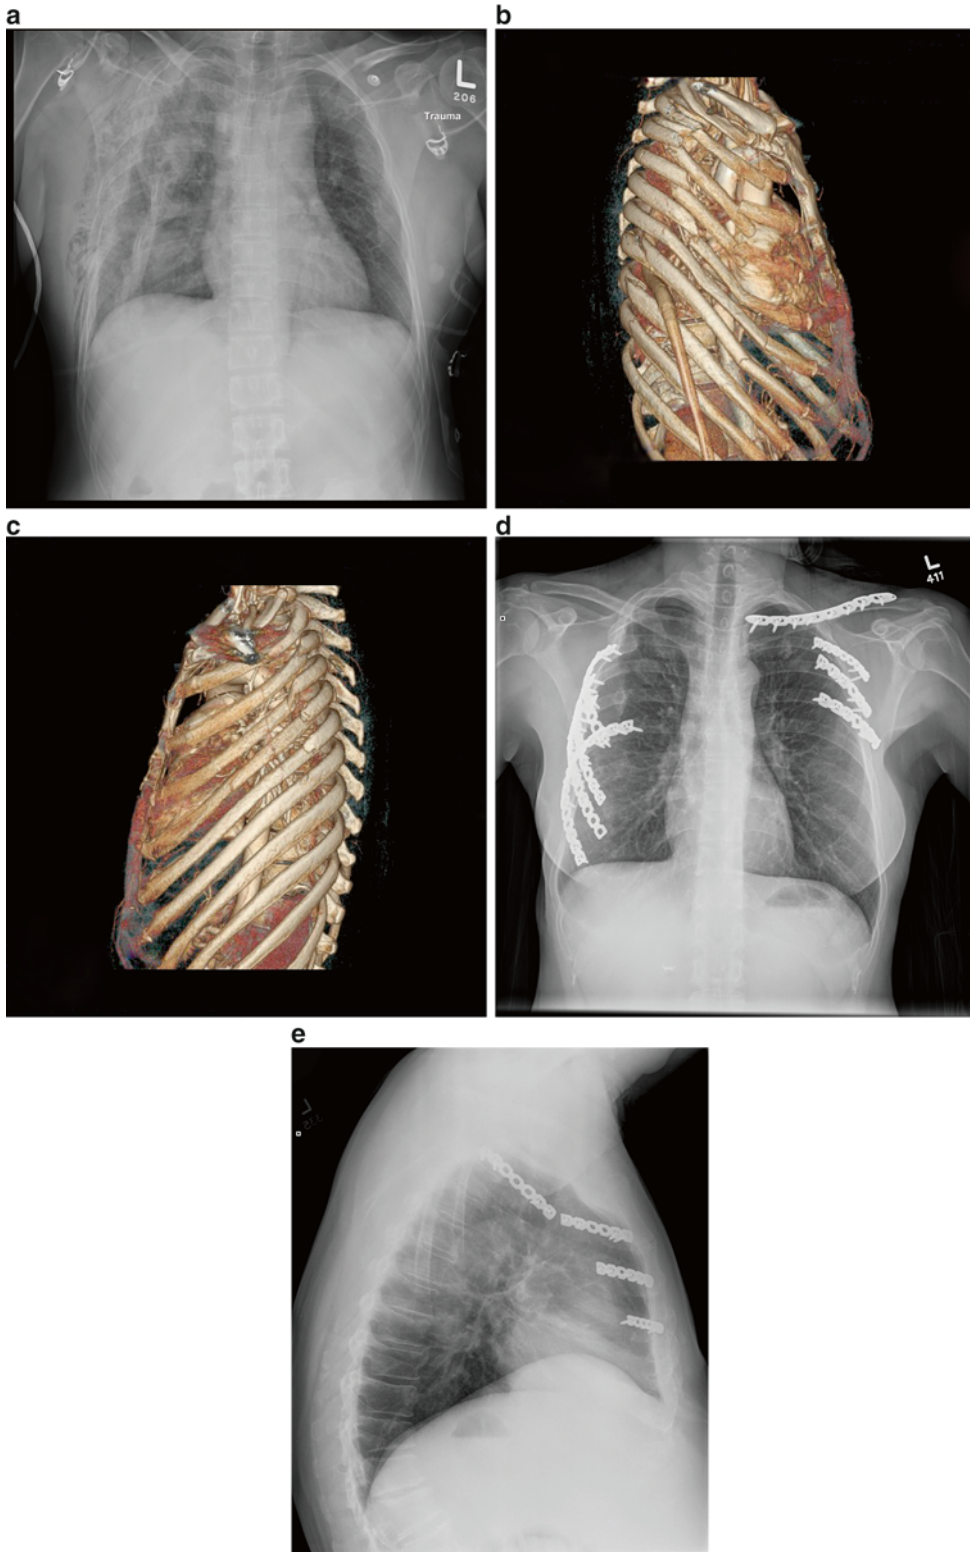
The chest radiograph (a) of a 49 year old female pedestrian struck by a vehicle suffering bilateral flail chest injuries and a fractured left clavicle. 3D CT reconstruction films reveal the deformity and fractures of the right (b) and left (c) sides of the chest wall. Postoperative radiographs (d, e) following operative fixation of the skeletal injuries
